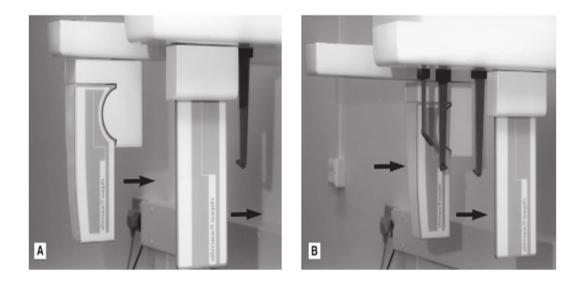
Close-up of the Planmeca cephalostat. A At the start of the exposure and B at the end. This equipment is designed to scan the patient horizontally with the X-ray beam, secondary collimator and sensor moving horizontally throughout the exposure (arrowed).
